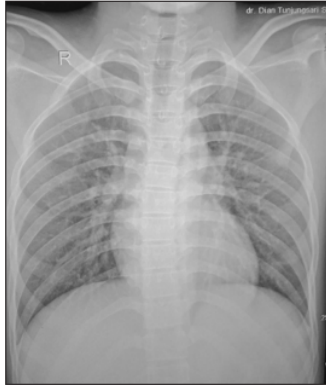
Chest radiograph of the patient. Radiographs showing bronchitis which include inflammation of the lower respiratory tract
